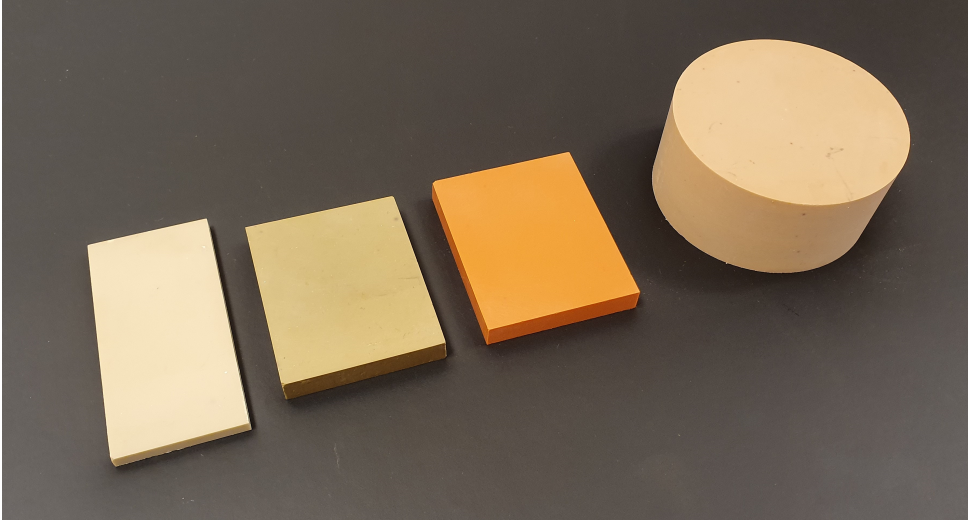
A variety of solid high permittivity material used in MRI. From left to right: lead zirconate titanate ($\epsilon_r = 1070$ and $\sigma = 1.5 \text{ S/m}$) used in Chapter 4, lead zirconate titanate ($\epsilon_r = 660$ and $\sigma = 0.01 \text{ S/m}$) used in Chapter 5, barium titanate with zirconium dioxide and ceric dioxide additives ($\epsilon_r = 4500$ and $\sigma = 1.79 \text{ S/m}$) used in Reference [45] and barium strontium titanate ($\epsilon_r = 165$) used in Reference [58]
